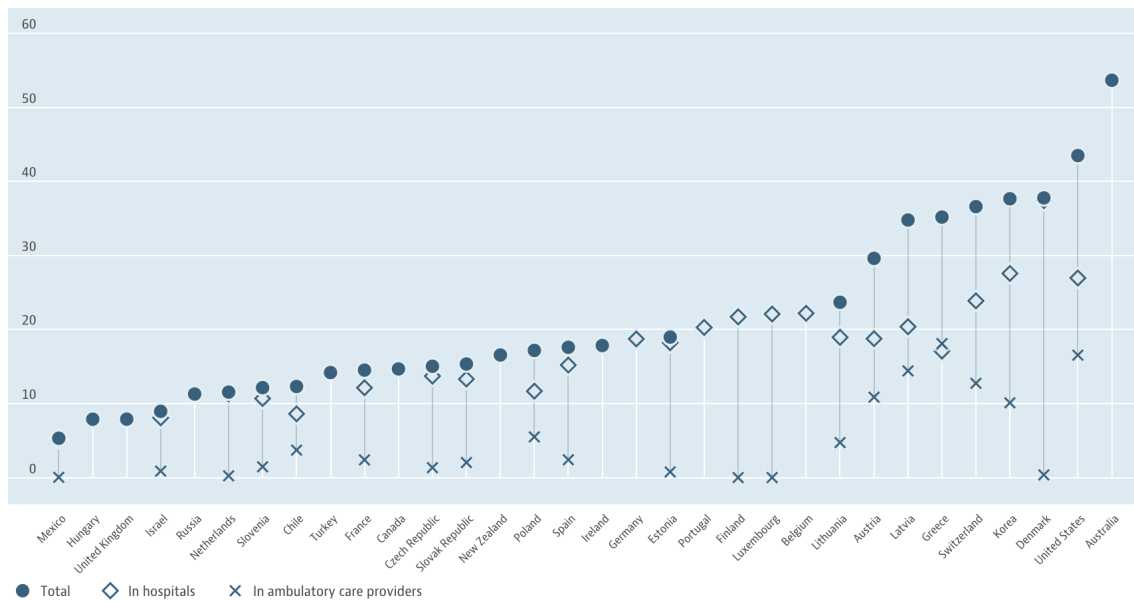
CT Scanners per million population OECD Health Data.
